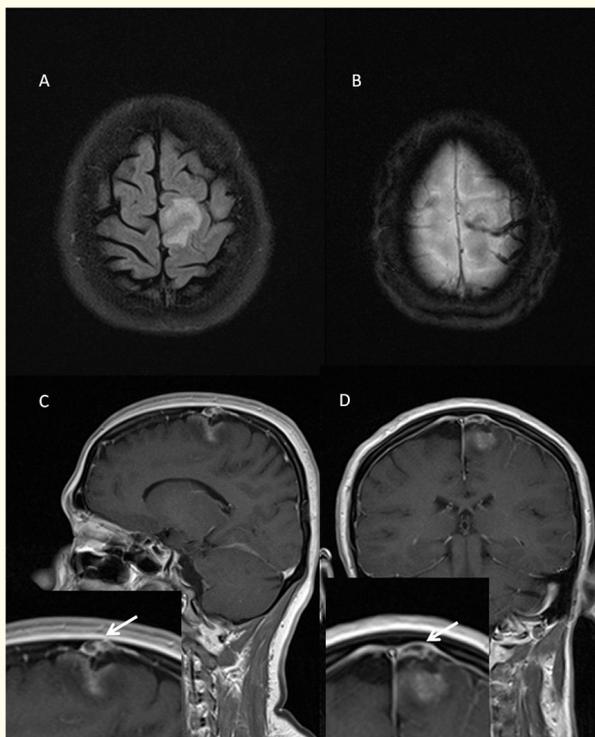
A) Unilateral high parietal signal change in FLAIR. B) GRE signals indicating thrombosis in the configuration of cortical veins. C, D) engorged and defected filling of cortical vein in T1 enhanced MRI images. (arrows in the below magnified images).
